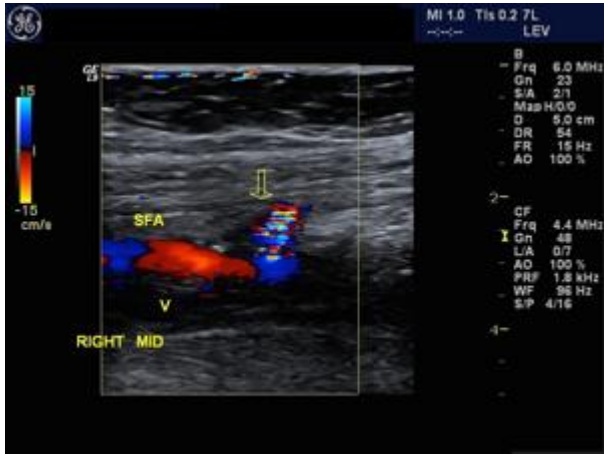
Color Doppler image of the mid right superficial femoral artery
